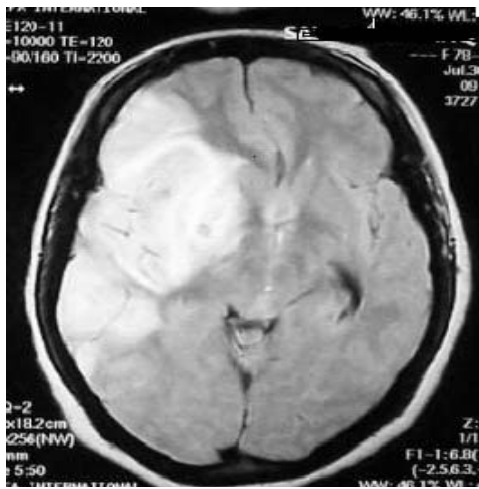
Axial flare MRI image of the brain showing full thickness right middle cerebral artery infarct.
